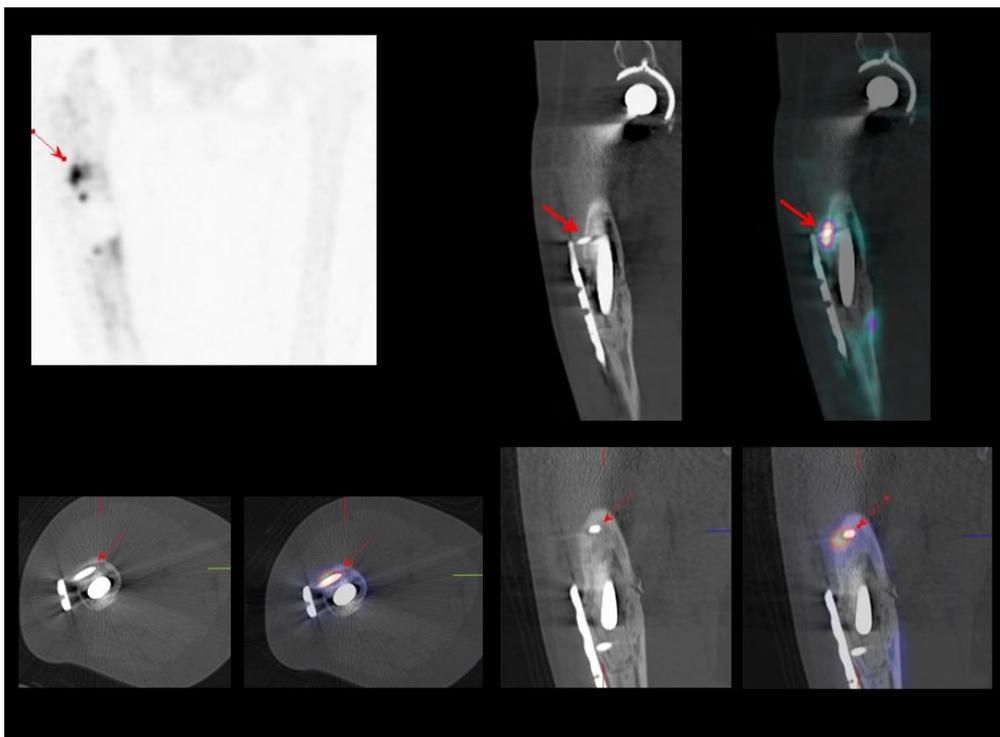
CT and fused SPECT/CT views delineate the extruded proximal screw separated from the shaft of the femoral component of the prosthesis with part of the screw and plate shifted away from the cortical margin. Focal uptake at the site of the extruded screw reflects the bony stress at the site of loosening.
